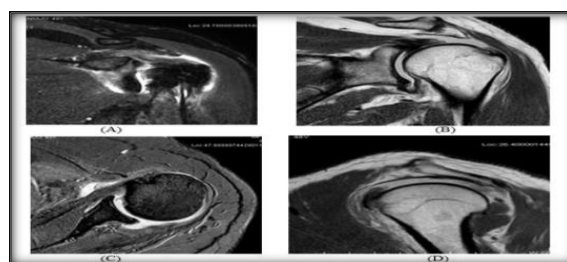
MRI images in coronal (A & B), axial (C), and sagittal (D), show a full-thickness tear of the supraspinatus.
